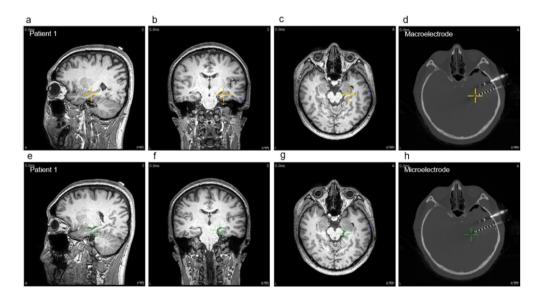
Electrode localization with structural MRIs. Shown are examples from one patient (see table 1 for demographic information). In the axis plane, the patient's left brain is on the left side. All images are T1 images, acquired with a Signa 1.5-tesla scanner (GE, Boston, MA, USA). Orange and green arrows always indicate an electrode in the macro electrode in the hippocampus, green in the microelectrdoe in the hippocampus. A-D. Example of macroelectrdoe localization A. Saggital image of the left side (T1). B. Coronal T1 image. C. Axial T1 image. D. Axial CT image. E-H. Example of microelectrode localization. E. Saggital image of the left side. F. Coronal image G. Axial image. H. Axial CT image of hippocampal microelectrode.
